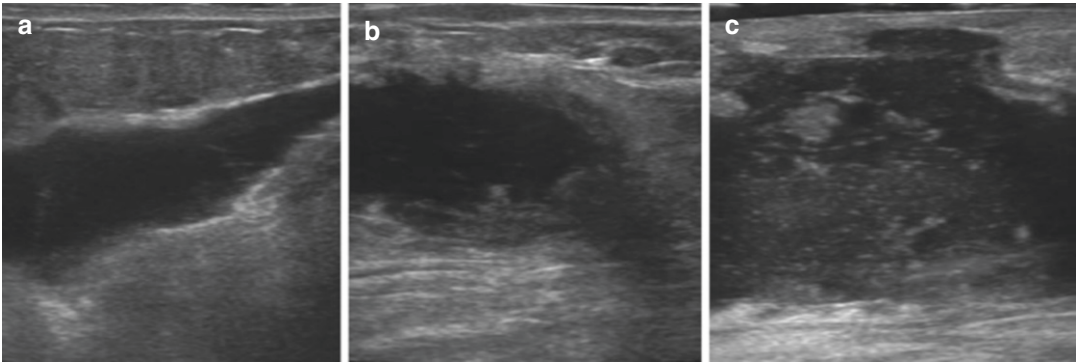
Ultrasound findings of postoperative seroma (a), hematoma (b), and abscess (c) on ultrasound. Note the progression in heterogeneity in the fluid collection
